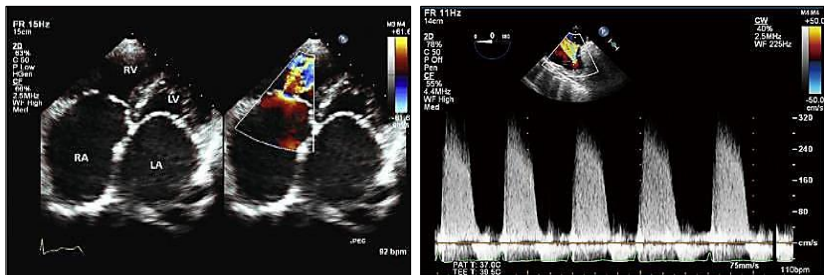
Tricuspid stenosis echocardiogram
